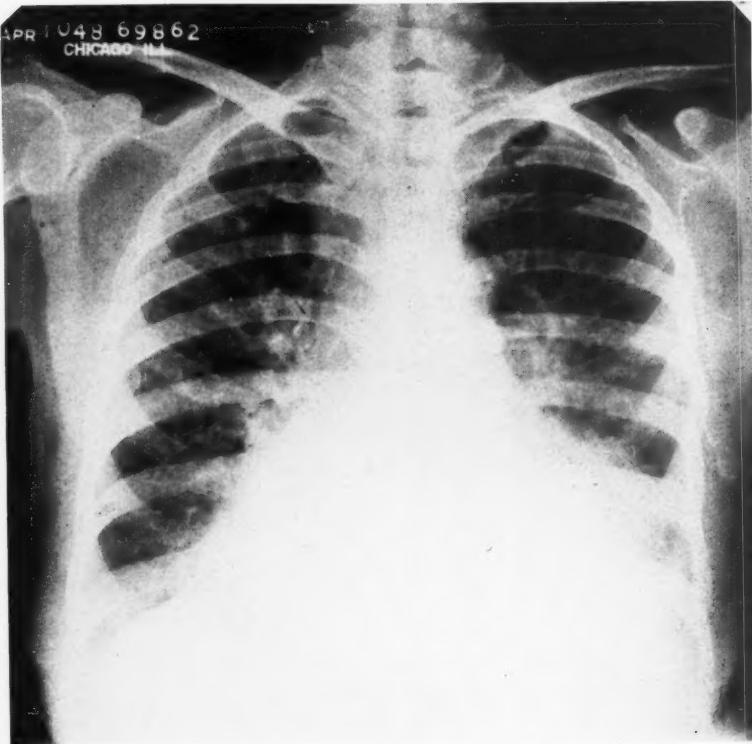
Posteroanterior roentgenogram of chest showing marked hypertrophy and dilatation
